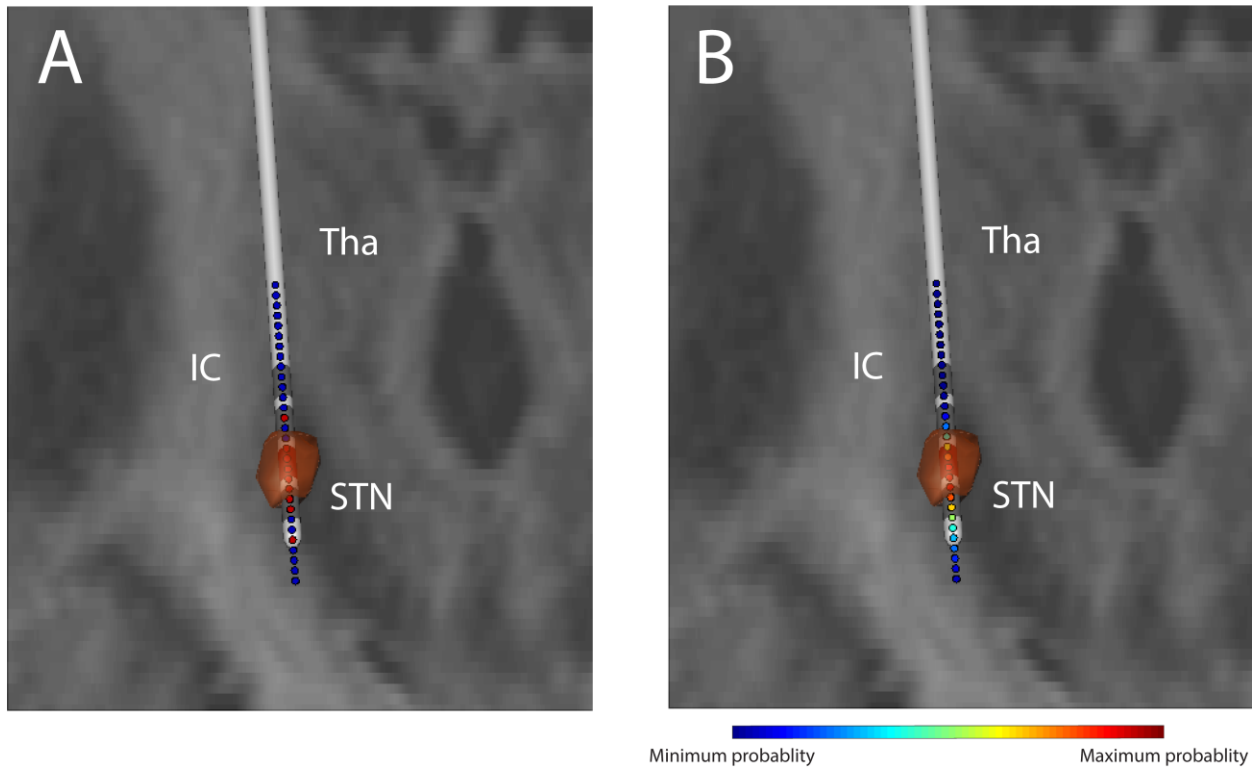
Patient example of algorithm predictions projected upon the corresponding COMSOL model of clinically effective tissue activation and patient MRI. (A) SVM binary predictions of clinically activated sites. Sites predicted to be within the therapeutic VTA (shown in orange) are indicated with red circles; sites predicted to be outside
